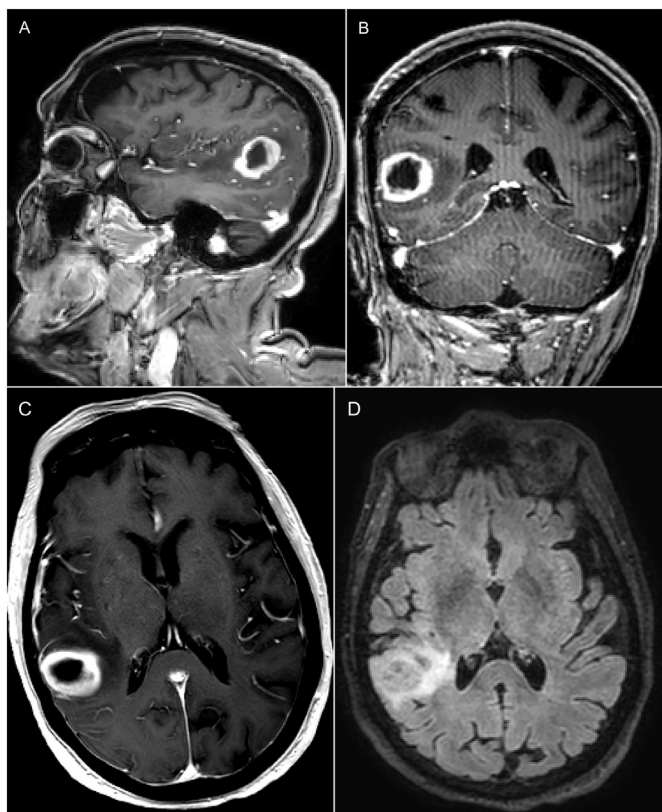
MRI: Post-contrast T1-weighted sagittal (1A), coronal (1B), and axial (1C) sections demonstrate a well-defined thick-walled ring-enhancing mass-centered in right temporo-occipital subcortical white matter. Axial FLAIR section (1D) showed intrinsic FLAIR intense signal with associated vasogenic edema and mass effect with effacement of adjacent sulci reaching up to right lateral ventricle without midline shift.
